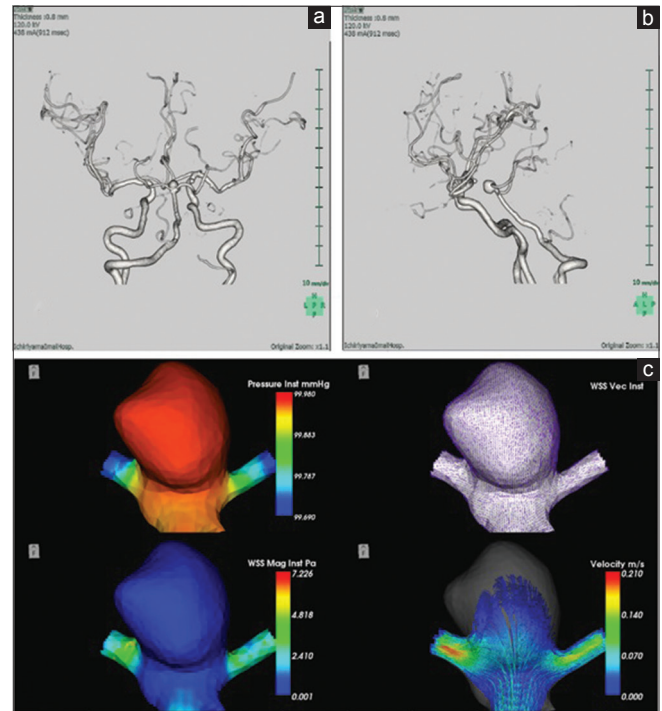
Three-dimensional computed tomography angiography of the brain and a computational fluid dynamics study on May 2, 2017. (a) Posterior view of three-dimensional computed tomography angiography of the brain; (b) Left view of three-dimensional computed tomography angiography of the brain; (c) Computational fluid dynamic study showing high wall pressure with low WSS pressure and WSS vector and the streamline within the basilar tip aneurysm sac. WSS: Wall stream stress
